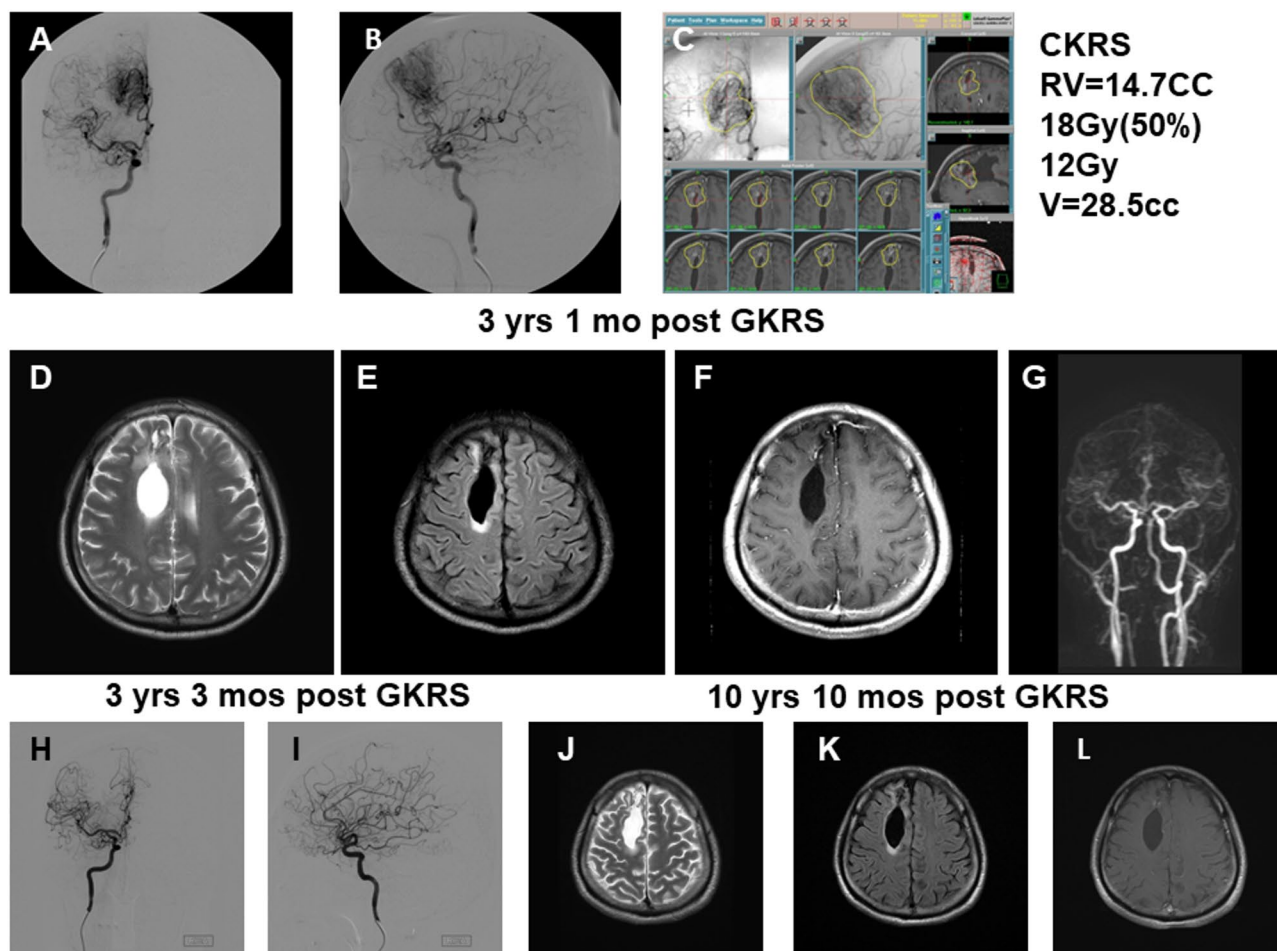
A 39-year-old male presented with right frontal hemorrhage and diagnosed as a huge AVM with volume of 14.7 cc. The treatment was conducted in single stage treatment according to the guidance of AVM volume 10–15 cc procedure in single stage. The post GKRS angiography showed the total obliteration after gamma knife and MRI showed a small cyst over the previous hemorrhage cavity. (A) A large right frontal AVM was detected in the anteroposterior view of cerebral angiography, with arterial supply from the anterior cerebral artery and venous drainage into the superior sagittal sinus. (B) A large right frontal AVM was observed in the lateral view of cerebral angiography, with feeding arteries from the anterior cerebral artery and drainage into the superior sagittal sinus. (C) Photograph showing dose planning for Gamma Knife radiosurgery (GKRS). Treatment parameters are displayed on the right side of the image. The yellow line indicates the 50% isodose line. (D) A small abnormal signal surrounding the cyst cavity in the right frontal region was observed on T2-weighted MRI 3 years and 1 month after GKRS. (E) A small abnormal signal surrounding the cyst cavity in the right frontal region was seen on FLAIR imaging 3 years and 1 month after GKRS. (F) Mild abnormal enhancement resembling a vascular structure was noted in the right frontal region on contrast-enhanced T1-weighted MRI 3 years and 1 month after GKRS. (G) A small nidus with early venous drainage in the right frontal region was detected on MRA 3 years and 1 month after GKRS. (H) Cerebral angiography in the anteroposterior view showed no definite nidus 3 years and 3 months after GKRS. (I) Cerebral angiography in the lateral view revealed no definite nidus 3 years and 3 months after GKRS. (J) A small cyst without progression was observed in the right frontal region on T2-weighted MRI 10 years and 10 months after GKRS. (K) A small cyst without progression was also observed on FLAIR imaging 10 years and 10 months after GKRS. (L) No definite abnormal enhancement surrounding the cavity was seen 10 years and 10 months after GKRS. Neurological examination revealed no definite neurological deficits
